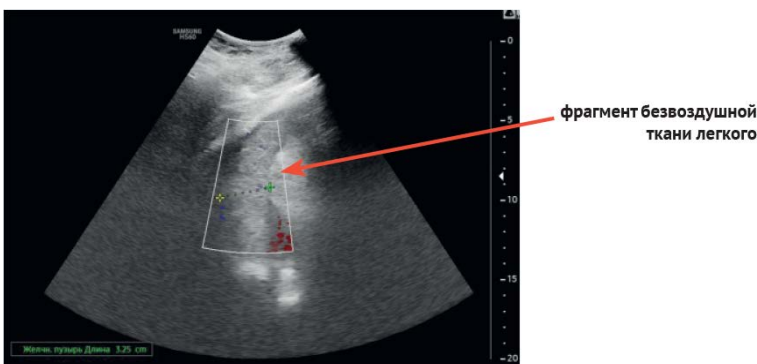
Ultrasound image of the contusion of the left lung. The ultrasound image shows a fragment of the lower lobe of the airless left lung, the structure with medium echogenicity, Color Doppler flow imaging does not trace arterial blood flow
